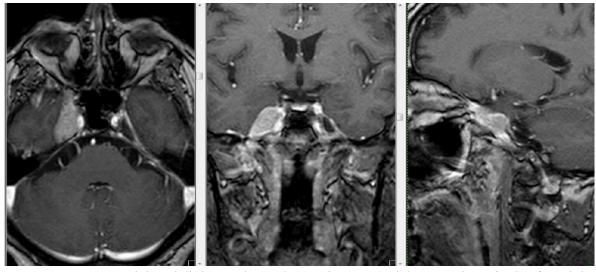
T1WI axial gadolinium-enhanced MRI images (axial, coronal, sagittal) after eight months, showing enlargement of the right cavernous sinus (from *Turliuc et al.*, 2016)
